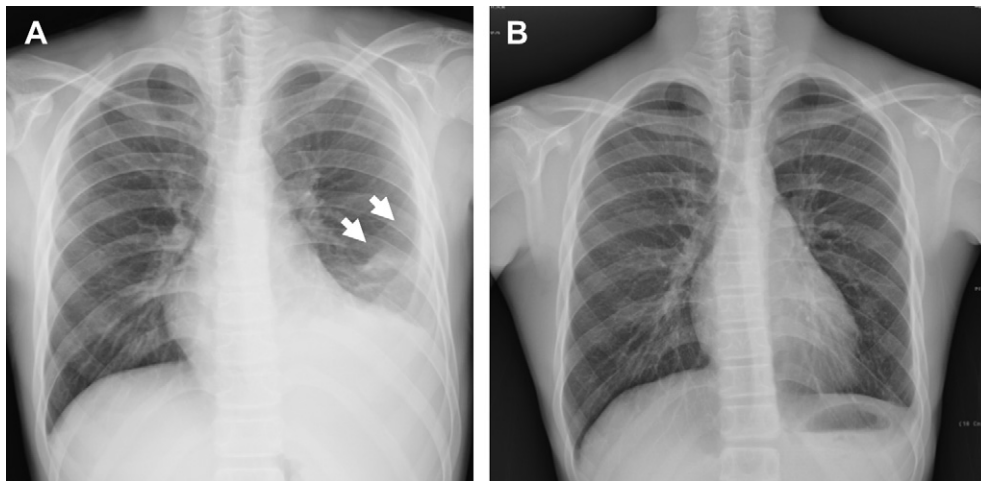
Primary tuberculosis (TB) infections: pleuritis with pleural effusion. (A) A 12-year-old boy was referred to our hospital because of massive pleural effusion without response to conventional antibiotics therapy. (B) There was no significant lung parenchyma involvement in the follow-up radiograph (after 6-month anti-TB treatment). Pleural effusion culture yielded *Mycobacterium tuberculosis* despite negative smear results. His grand-aunt was also diagnosed with pulmonary TB.
